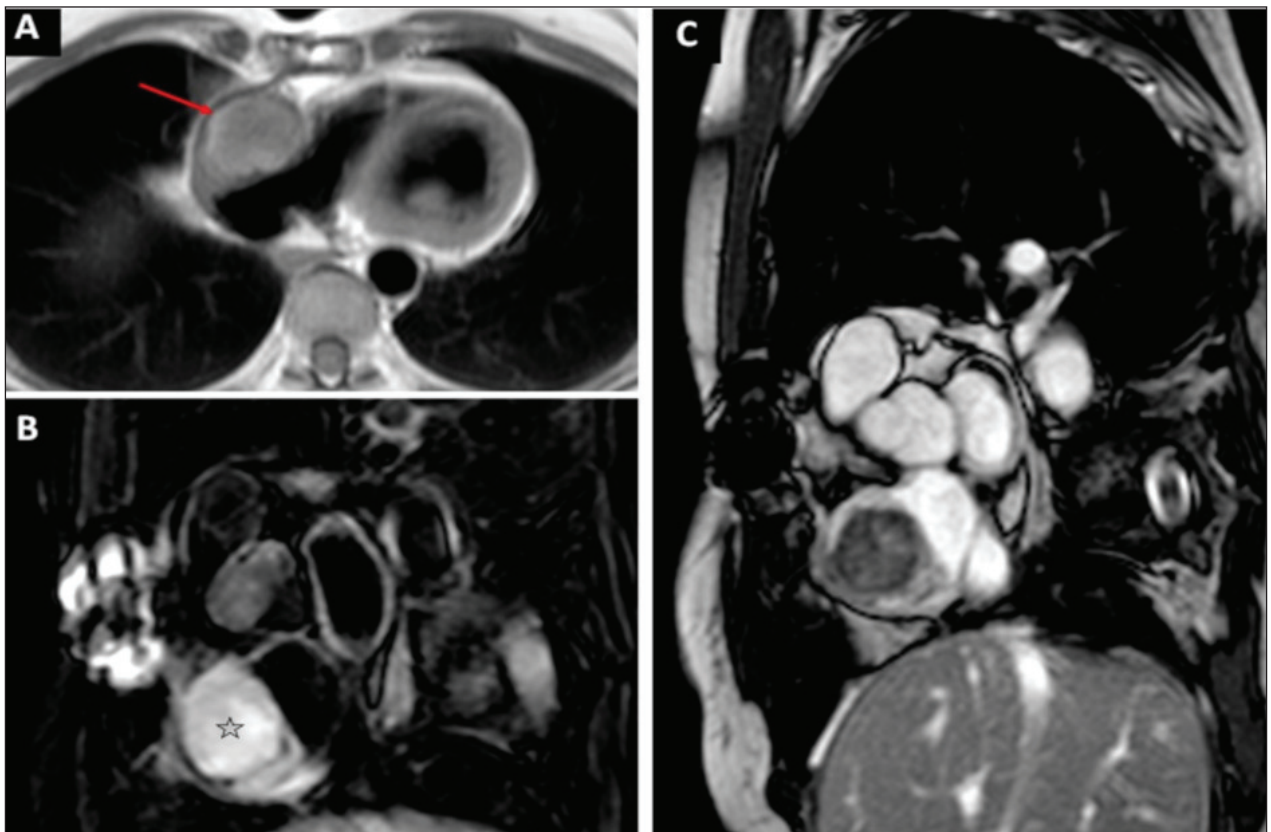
Right atrium angiosarcoma treated with radiotherapy- 57-year-old female. Large with a broad-based mass into the right atrium associated to thickening of the pericardium (red arrow), predominantly isointense to myocardium on T1-weighted image (A). On T2-weighted image, SPIR, the mass shows a typical and high signal hyperintensity (star) (B); heterogenous appearance on balance cine sequences (C).
